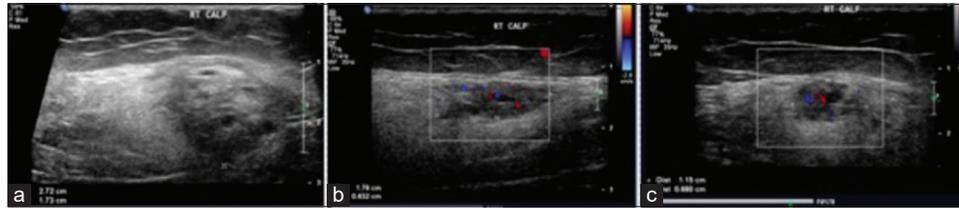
Ultrasound images demonstrating a heterogeneous intramuscular mass with cystic areas (a). There is hypervascularity on color Doppler imaging (b). Appearances are in keeping with a vascular lesion (c).
